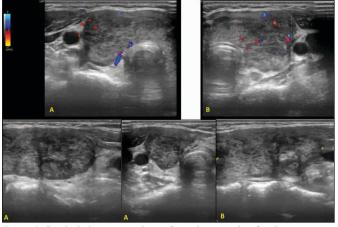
Cervical ultrasonography performed two weeks after the emergency department discharge.
